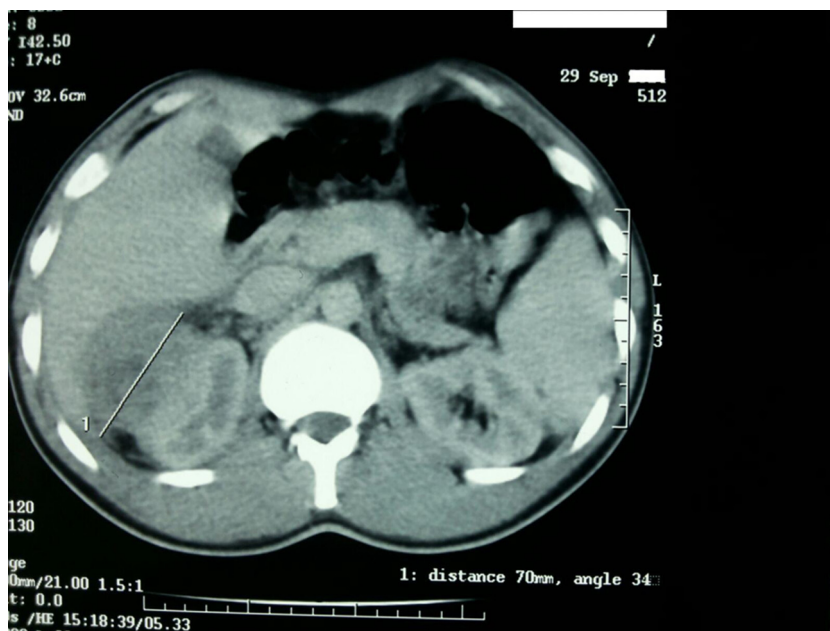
A non-contrast CT axial view of the abdomen showing an upper pole mass of the right kidney with close contact with liver.
